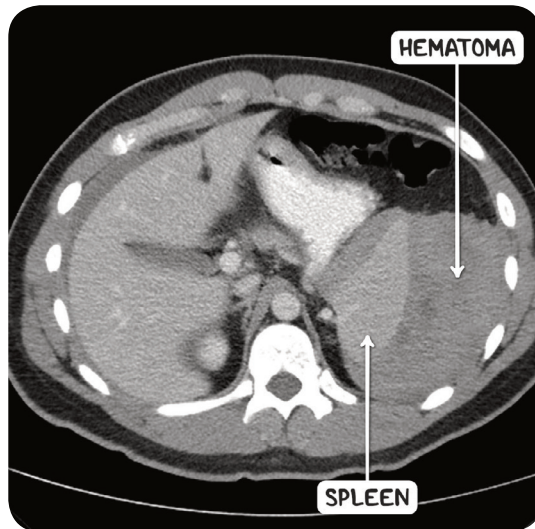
An abdominal CT scan in the axial plane demonstrating a large perisplenic hematoma. This hematoma has formed as a result of splenic rupture, most likely as a result of trauma.
